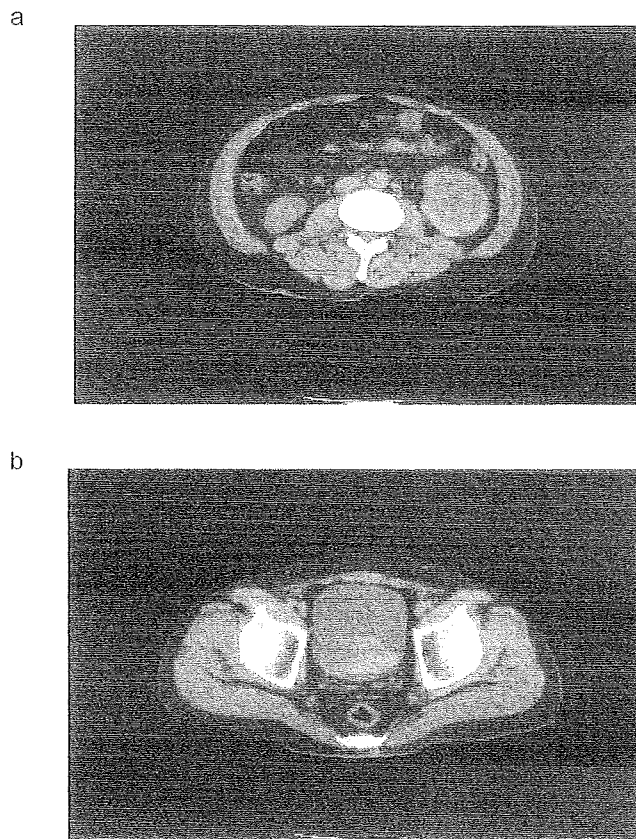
CT scan shows a large perinephric, intracapsular hematoma of left kidney.
